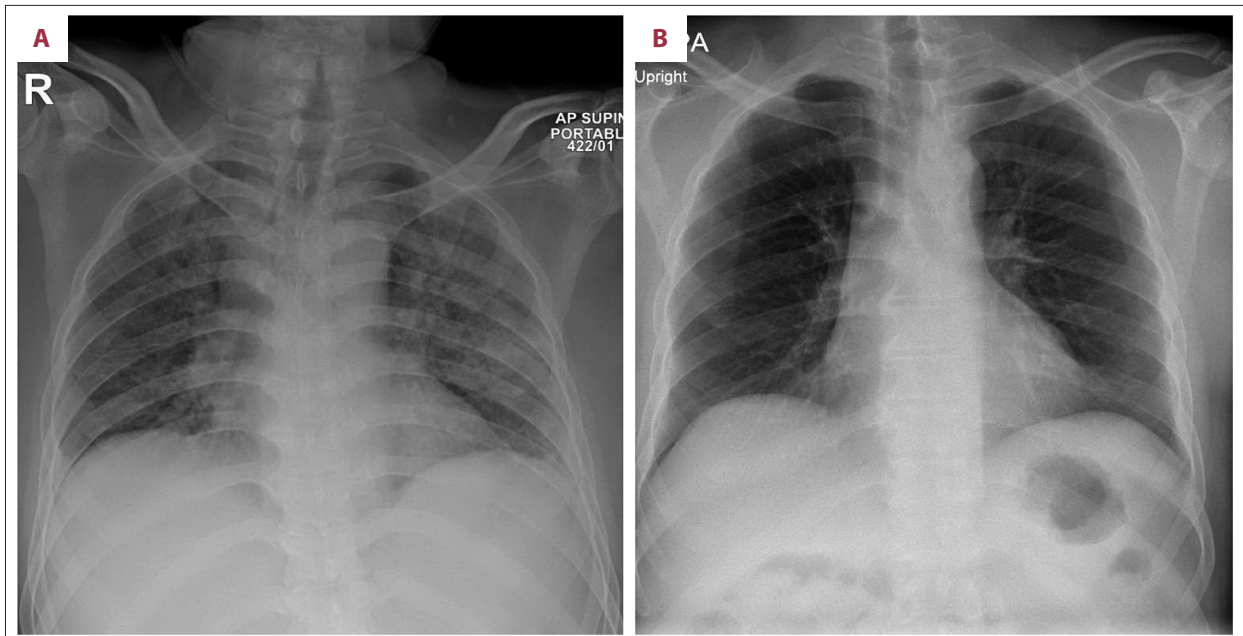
Chest X-ray (CXR) (A. Initial CXR showing bilateral pulmonary opacities, B. Follow-up CXR showing post-treatment resolution of opacities).
